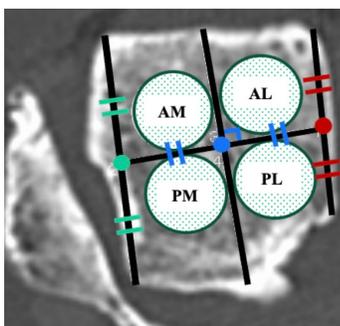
The axial CT image 7mm below the talar dome is used. Using a standard annotation feature, a circular region of interest (ROI) is drawn 4areas: AM: anteromedial, AL: anterolateral, PM: posteromedial, PL: posterolateral
